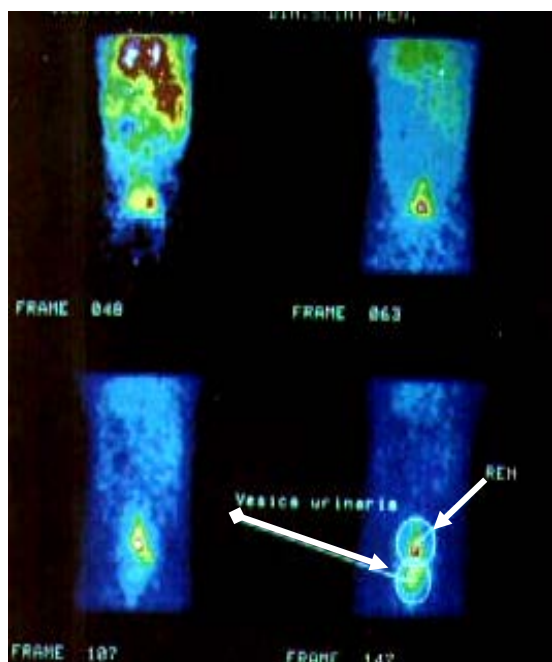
Dynamic nephroscintigraphy.
